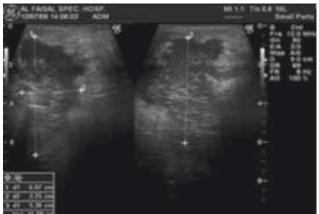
Ultrasound showing typical features of eumycetoma
